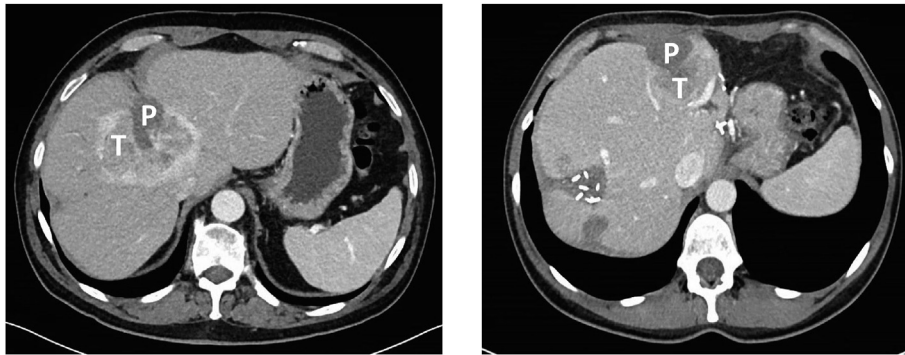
Local tumour progression within or in direct contact with the post-ablation zone. Examples of computed tomography follow-up imaging after combined resection and ablation for colorectal liver metastases. *P* post-ablation zone, *T* local tumour progression
